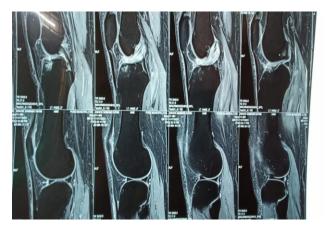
Sagittal section of MRI showing intact ACL with hypertrophic mucoid degeneration.
